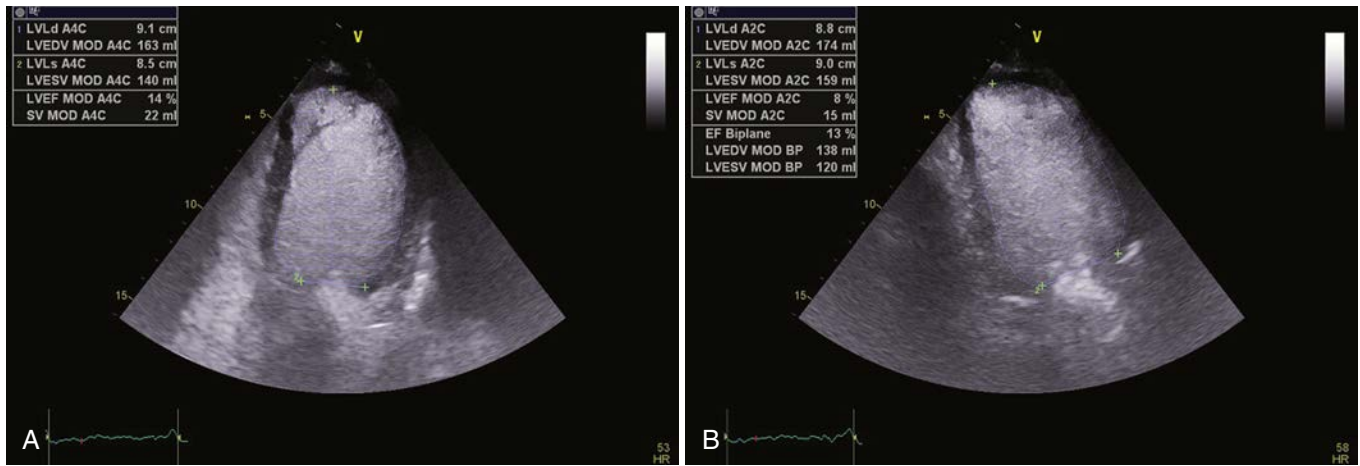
Left ventricular (LV) opacification using contrast ultrasound agent. Evaluation of LV volumes and systolic function using the Simpson's method of disks after injection of lipid-shelled, gas-filled encapsulated microbubbles (echocardiographic contrast agent, Definity). The LV endocardial borders are traced at end systole and end diastole in two orthogonal views: the apical four-chamber (A) and two-chamber (B) views. The LV end-diastolic and end-systolic volumes (LVEDV, LVESV) and the LV ejection fraction (LVEF) are derived. V, XXXXXXXXX.
